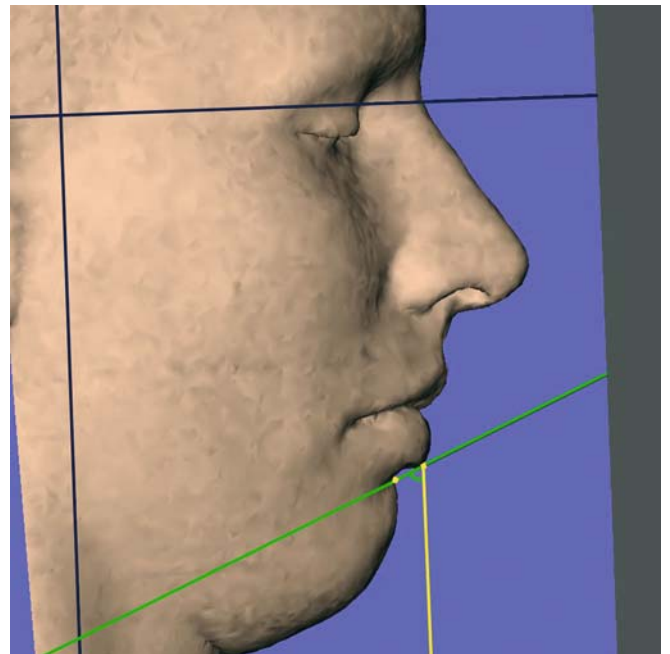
The inclination of the lower lip from the vertical plane, $li-sl / y$ -plane, is a projected angular soft tissue measurement on the median (z) 3-D cephalometric reference plane (3-D CT, soft tissues, patient K.C.)
